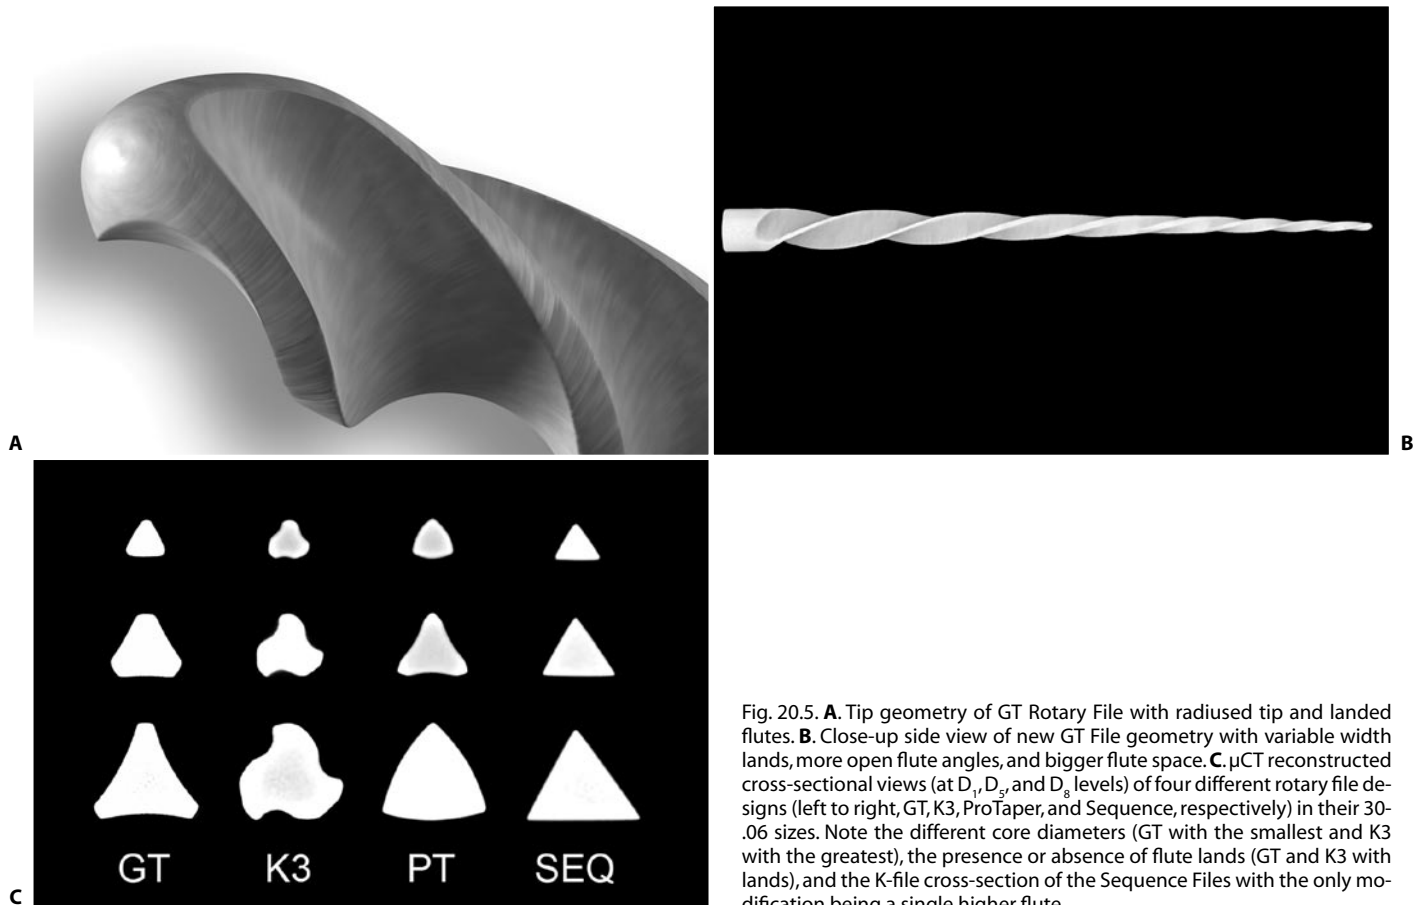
A. Tip geometry of GT Rotary File with radiused tip and landed flutes. B. Close-up side view of new GT File geometry with variable width lands, more open flute angles, and bigger flute space. C. μ CT reconstructed cross-sectional views (at D_1 , D_3 , and D_8 levels) of four different rotary file designs (left to right, GT, K3, ProTaper, and Sequence, respectively) in their 30-.06 sizes. Note the different core diameters (GT with the smallest and K3 with the greatest), the presence or absence of flute lands (GT and K3 with lands), and the K-file cross-section of the Sequence Files with the only modification being a single higher flute.
